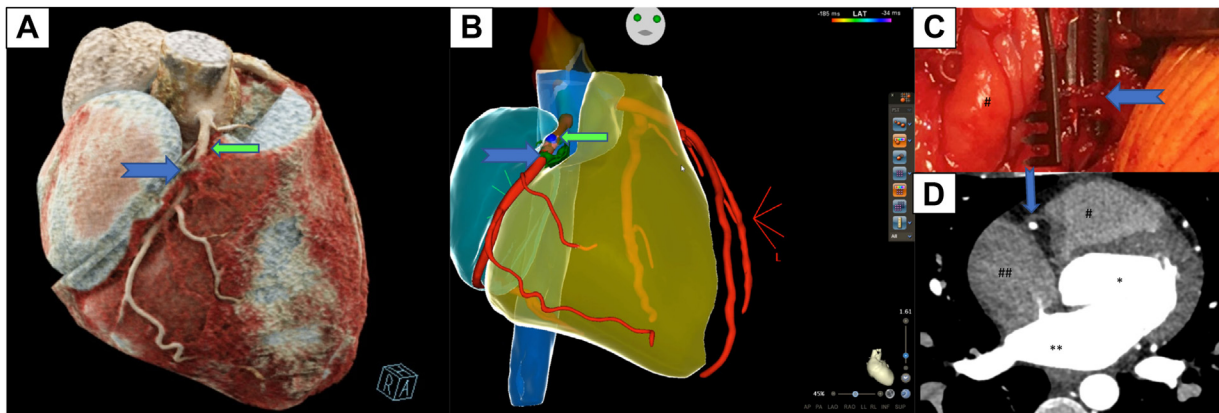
Three-dimensional reconstruction of cardiac computed tomographic (CT) scan (A) and result of merged CT scan and CARTO mapping of the right coronary artery (RCA) and aortic root (B) showing the myocardial bridge crossing the RCA and the earliest ventricular activation, respectively. C: Accessory pathway (AP) and surgical situs before AP dissection as viewed from the patient's head with the right ventricle on the left. D: Cross-sectional CT scan of the myocardial bridge. Blue arrow indicates myocardial bridge with accessory pathway. Green arrow indicates earliest ventricular activation. *Left ventricle; left atrium; #right ventricle; ##right atrium.
